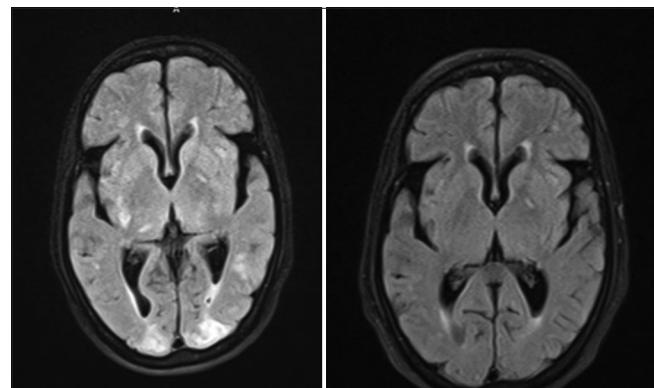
FLAIR Sequence showing left > right occipital hyperintensities and mild hyperintensity in right internal capsule area and follow-up imaging after 1 month shows resolution of lesions
